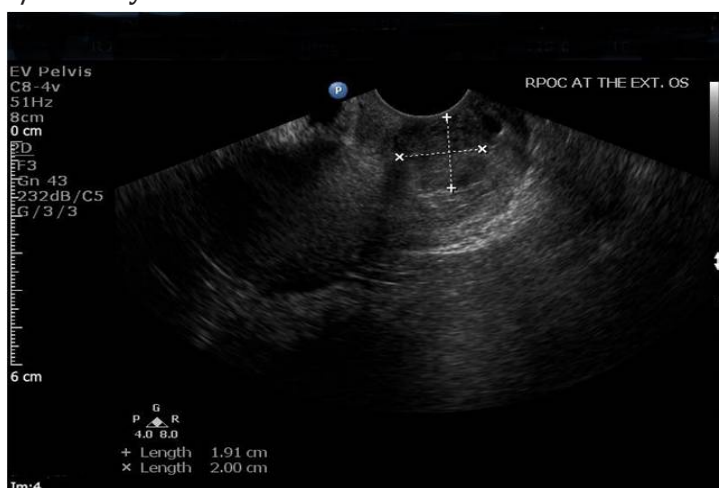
The trans-vaginal ultrasound scan picture on day 13 of treatment showing area of suggested retained products of conception
